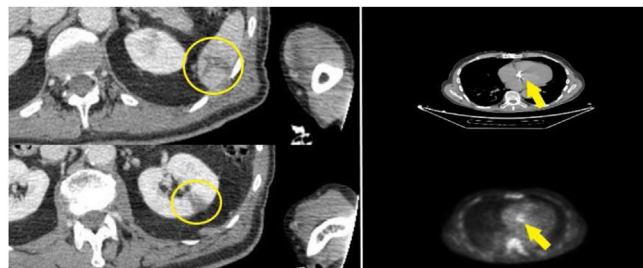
Joint CT and PET-CT study performed following endocarditis protocol after inconclusive result by transoesophageal echocardiogram by administration of intravenous contrast and 18-FDG, with imaging from the cervical region up to and including the pelvis. Hypodense lesions of triangular morphology and new appearance in the lower pole of the spleen and interpolar region of the left kidney, compatible with small infarcts (yellow circles). Focal increase in metabolic activity (yellow line) on the prosthetic aortic valve annulus's anterior region makes it impossible to rule out endocarditis without significant morphological findings.
